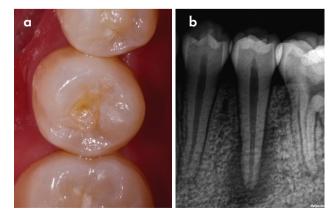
(a) Pre-op intra-oral photograph of mandibular left second premolar showing a small tubercle on the occlusal surface; (b) Peri-apical radiograph showing large peri-apical radiolucent lesion around the apex of the mandibular second premolar
